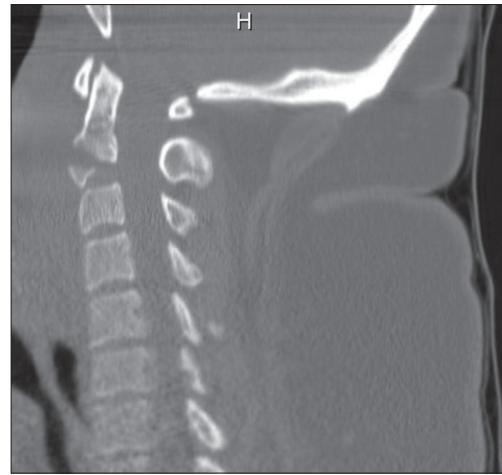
Sagittal CT imaging demonstrating the fracture extending through to the posterior portion of the C2 end plate
